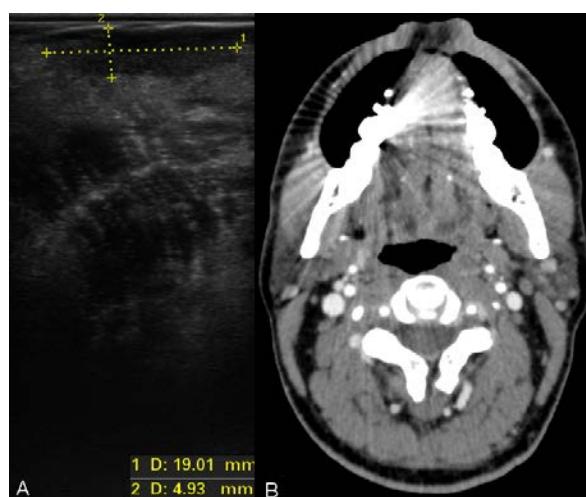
Oral cavity carcinoma (OCC) localized on the lateral edge of the tongue with measured DOI and GD: A) IOUS shows a hypoechoic and not sharply demarcated lesion towards the deeper tissues of the tongue; B) A transversal CT scan showing that it was not possible to detect OCC due to the presence of artifacts originating from metal dental restorations. IOUS – intraoral ultrasound; DOI – depth of invasion; CT – computed tomography; GD – greatest dimension.
